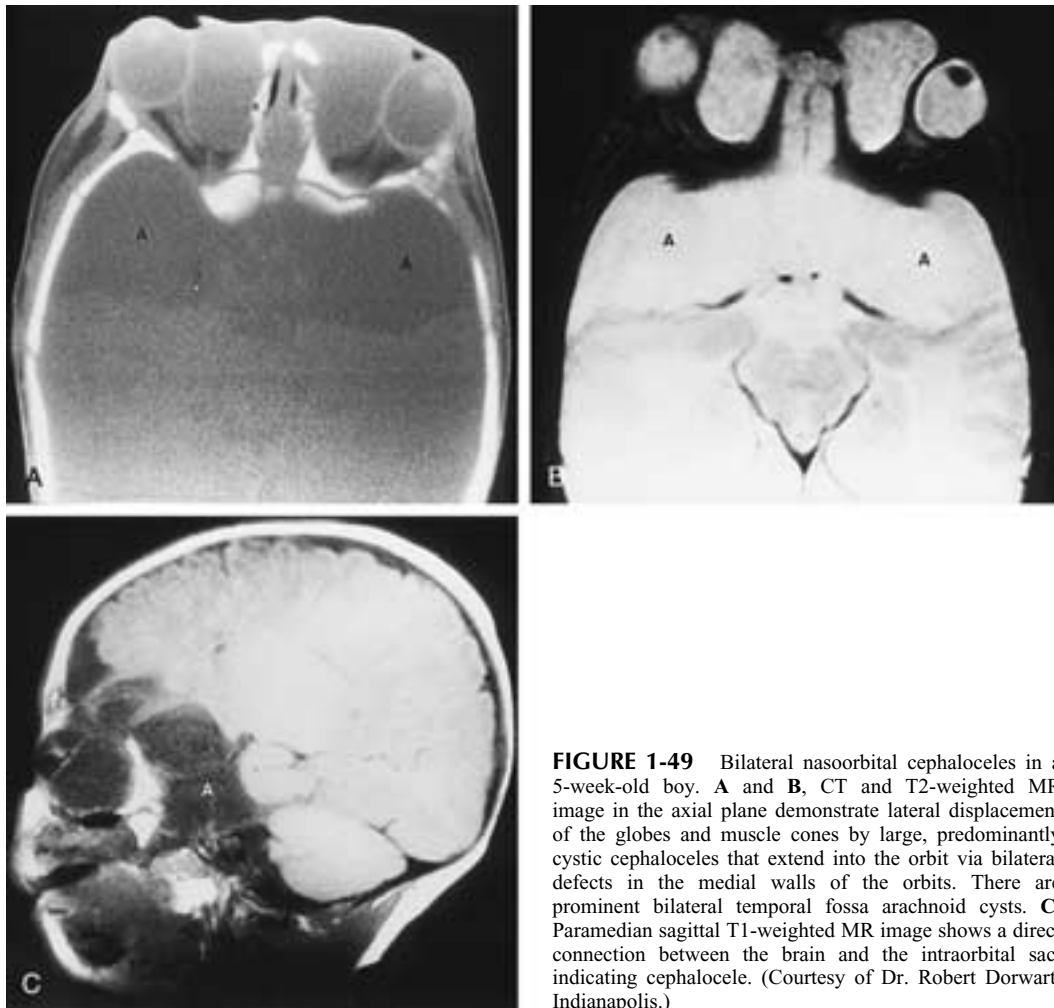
Bilateral naso-orbital cephaloceles in a 5-week-old boy. A and B, CT and T2-weighted MR image in the axial plane demonstrate lateral displacement of the globes and muscle cones by large, predominantly cystic cephaloceles that extend into the orbit via bilateral defects in the medial walls of the orbits. There are prominent bilateral temporal fossa arachnoid cysts. C, Paramedian sagittal T1-weighted MR image shows a direct connection between the brain and the intraorbital sac, indicating cephalocele. (Courtesy of Dr. Robert Dorwart, Indianapolis.)
